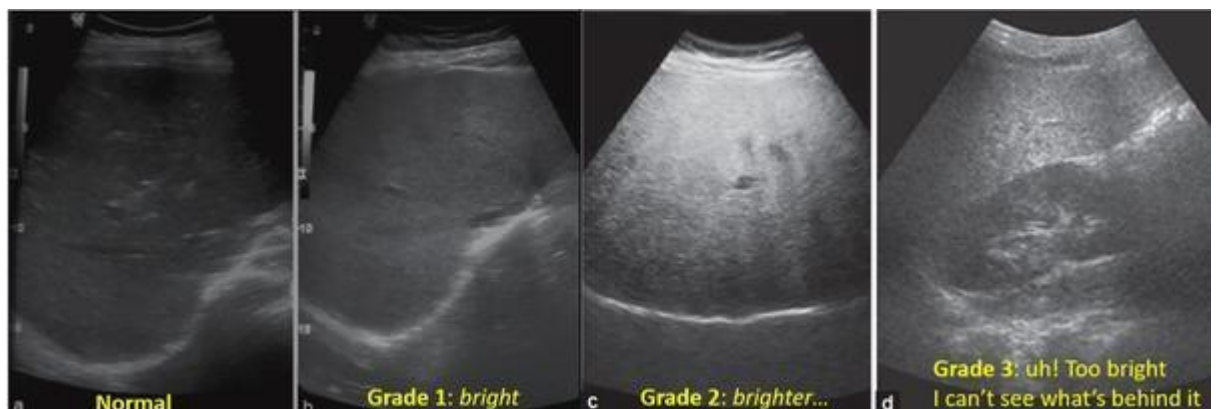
Grading of liver through ultrasonography
